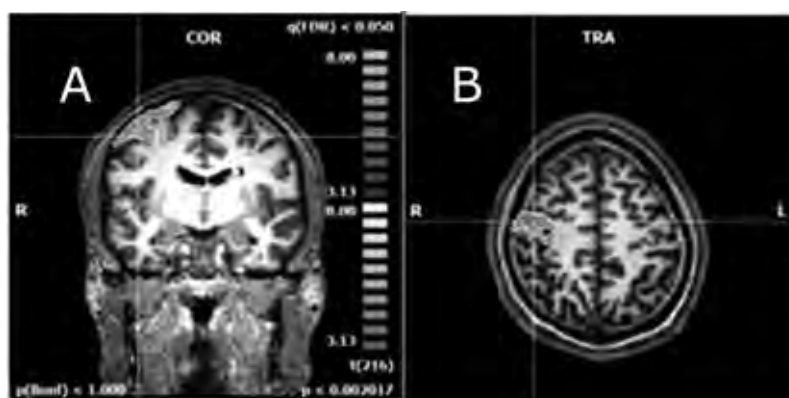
Functional MR image of the brain in frontal (A) and transversal (B) plane. The images show the activity of the motor cortex of the right hemisphere when the left elbow extensors exerted maximum isometric force.
